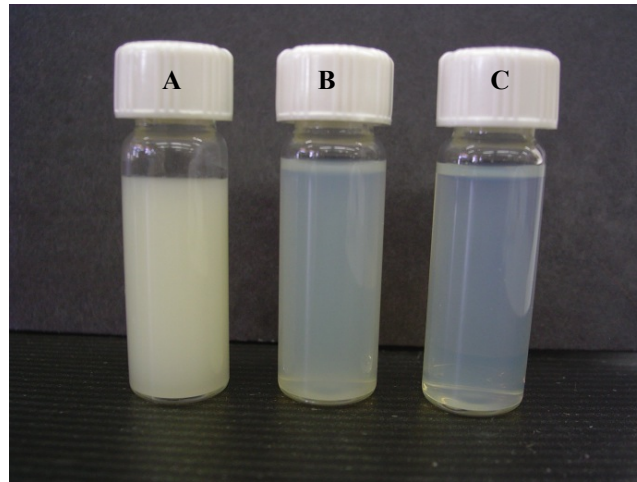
Coarse emulsion (A) and nanoemulsions treated by ultrasounds for 60 s (B) and 180 s (C) at 100 μm containing lemongrass oil (1% v/v), alginate (1% w/v) and tween 80 (1% v/v).
